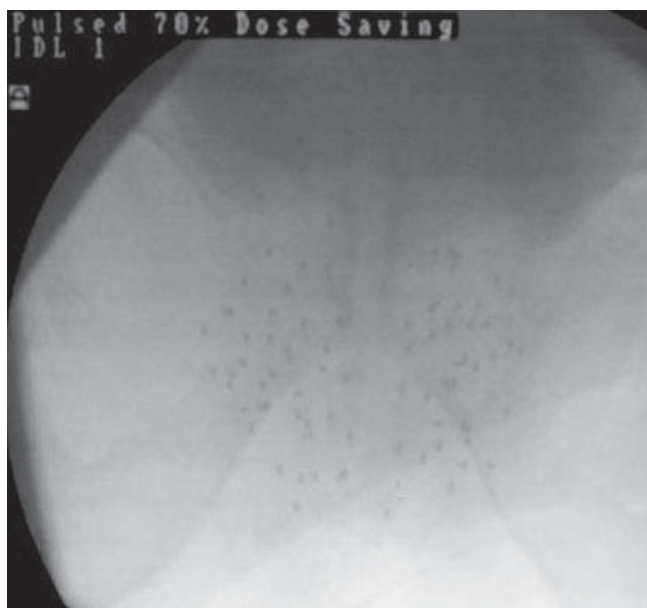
On-table x-ray immediately following implantation showing good seed distribution.
